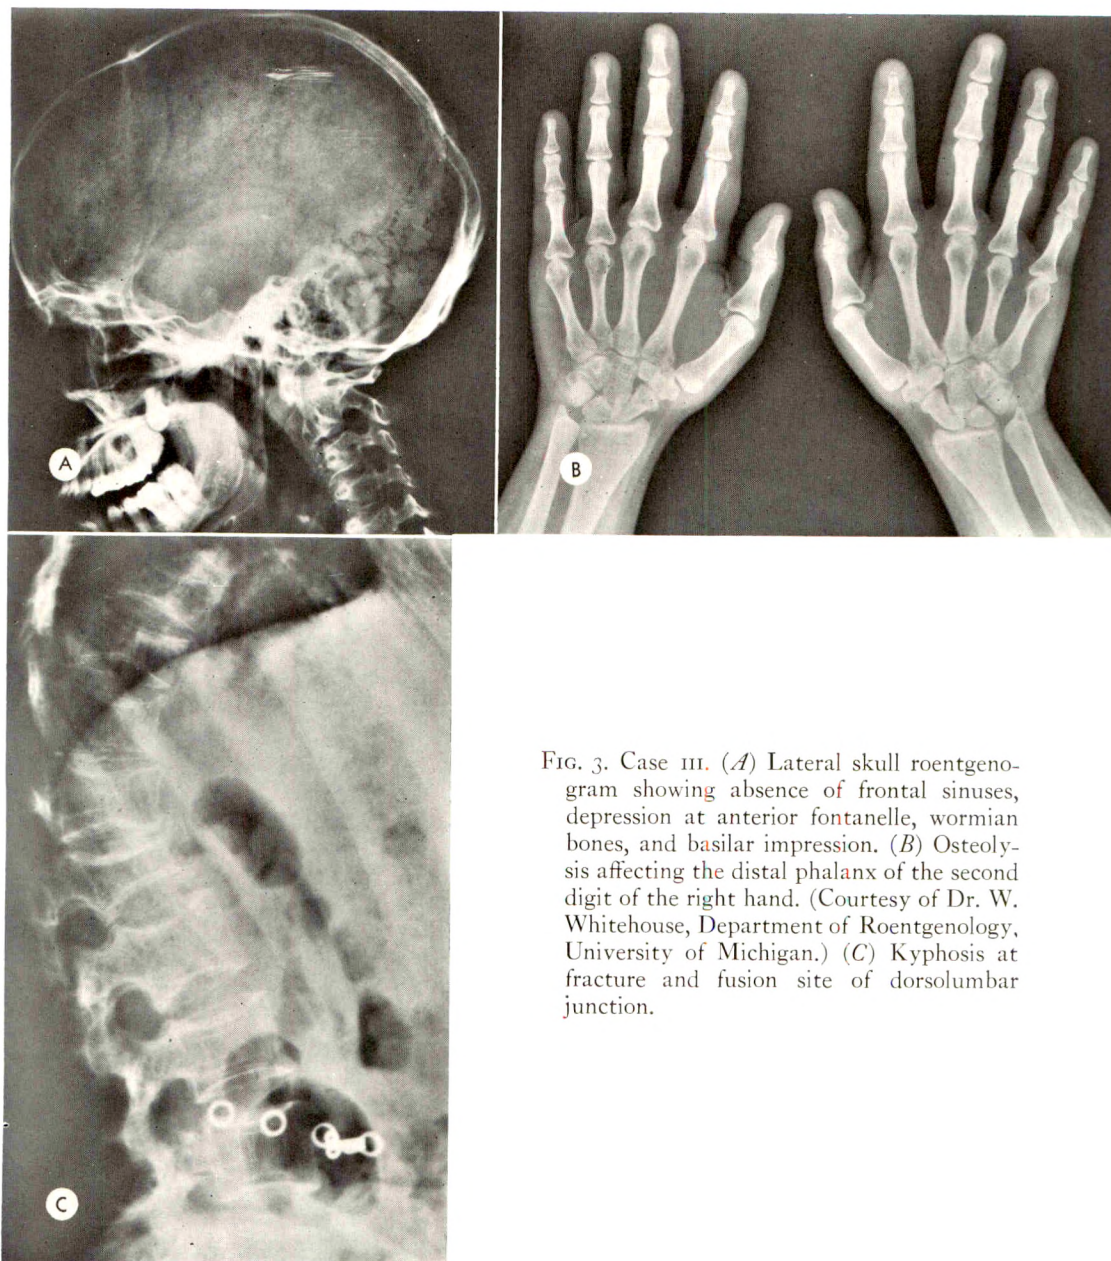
Case III. (A) Lateral skull roentgenogram showing absence of frontal sinuses, depression at anterior fontanelle, wormian bones, and basilar impression. (B) Osteolysis affecting the distal phalanx of the second digit of the right hand. (Courtesy of Dr. W. Whitehouse, Department of Roentgenology, University of Michigan.) (C) Kyphosis at fracture and fusion site of dorsolumbar junction.
